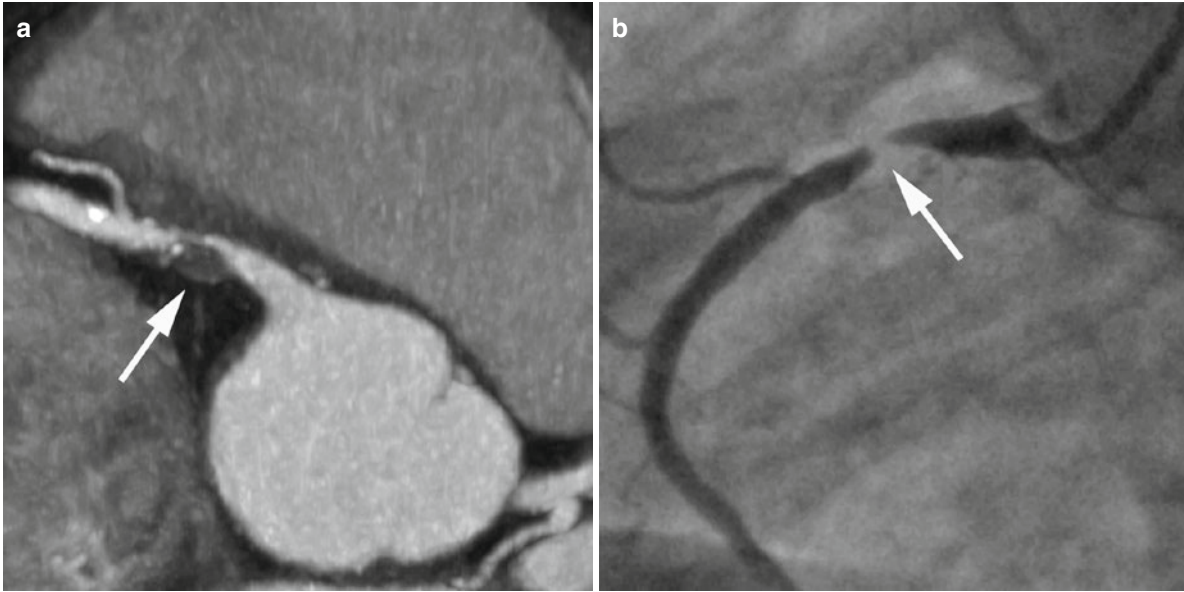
Chronic total occlusion of the proximal right coronary artery with characteristics that indicate challenging conditions for interventional revascularization. (a) Coronary CT angiography shows a total occlusion of the right coronary artery with massive calcifications (*large*
